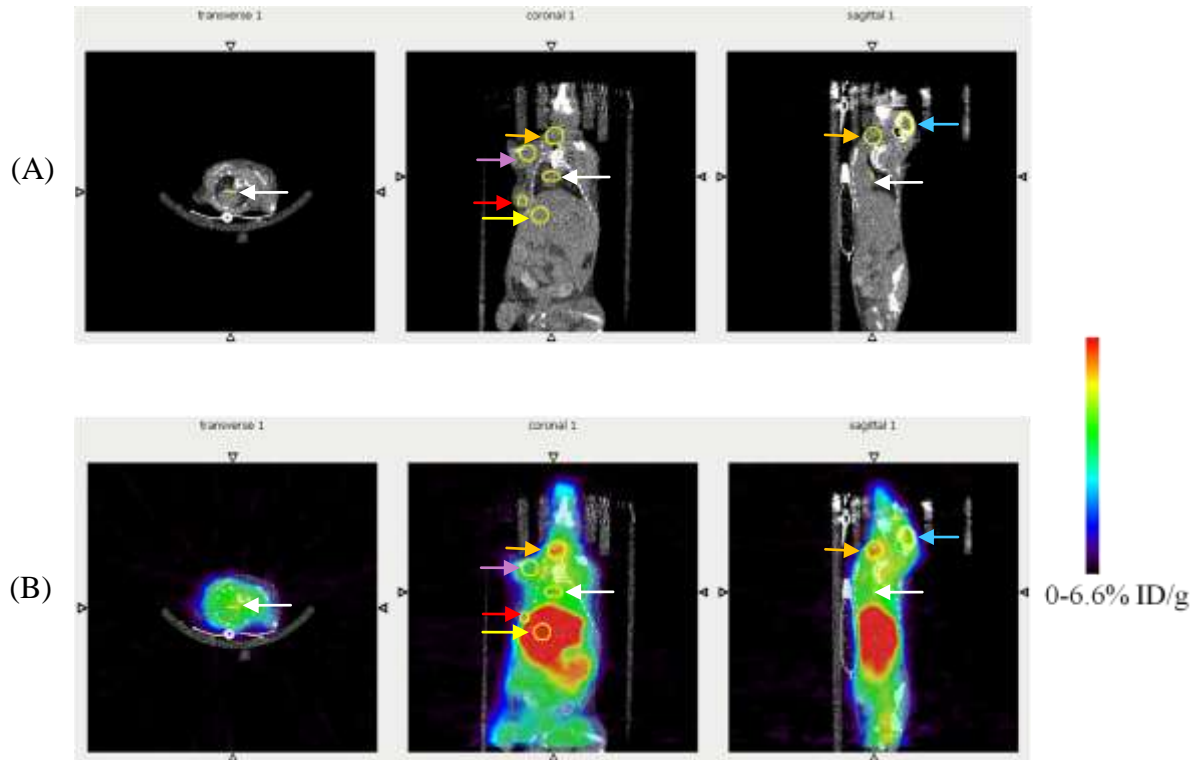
Dynamic PET image 15-16 minute pi. ROIs for tumour (coronal view; red arrow), liver (coronal view; yellow arrow), throat (coronal and sagittal view; orange arrow), front leg muscle (coronal view; purple arrow) and heart (transverse, coronal and sagittal view, white arrow). (A) CT image, (B) PET/CT image. PET colour indicating 0 - 6.6% ID/g
